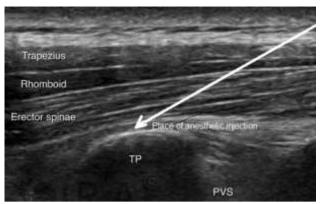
Ultrasound visualization of the place of hneedle positioning and local anesthetic injection
